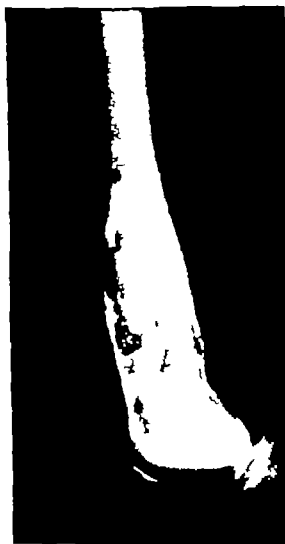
Roentgenogram of a relatively early chondrosarcoma in the lower end of a femur developing apparently on the basis of an old calcified and ossified enchondroma. The tumor has induced appreciable widening of the shaft and appears to be penetrating its cortex.
